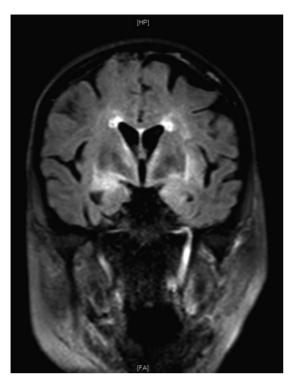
Bilateral medial temporal abnormal T2/FLAIR signal.
